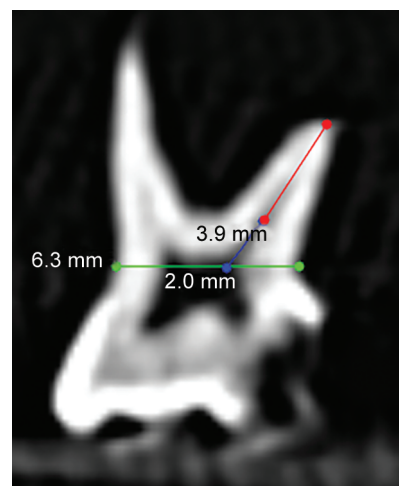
Volumetric analysis done in the CBCT image
